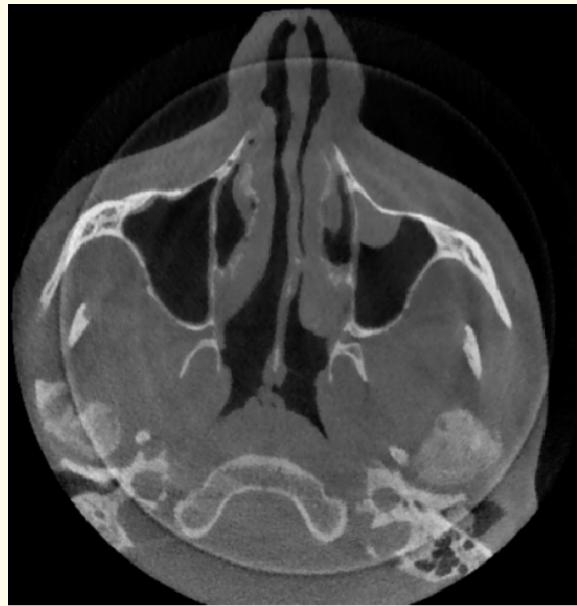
AAxial section of CBCT showing deformed condylar processes of mandible.
